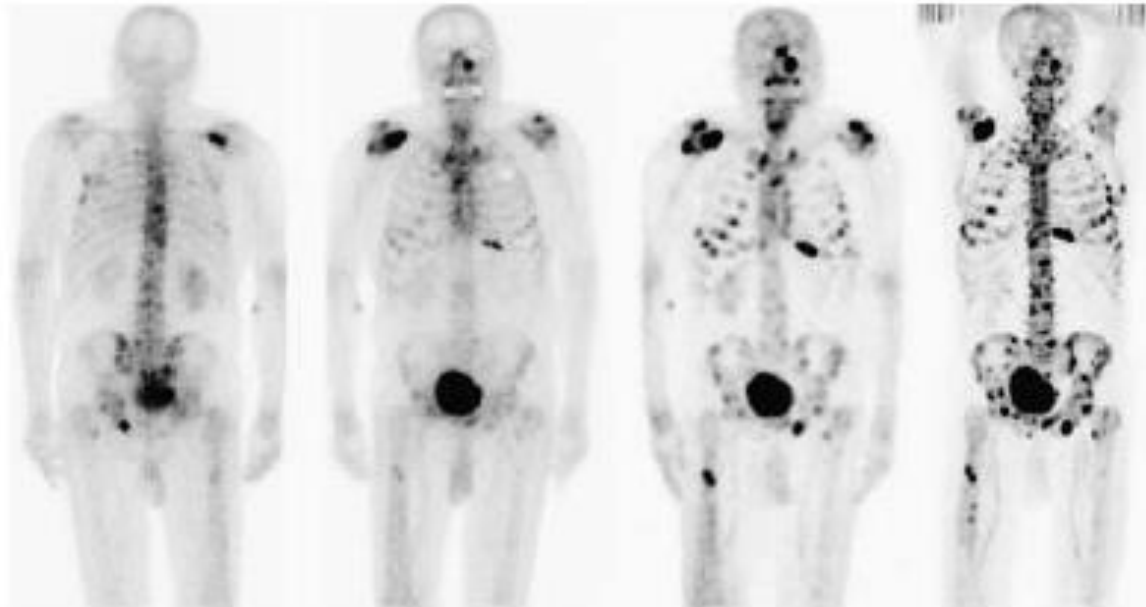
An 82-y-old patient with numerous bone metastases. From left to right: posterior and anterior planar BS, multi-FOV SPECT, and ^{18}F -Fluoride PET images. More lesions are detected on SPECT compared with planar images and on ^{18}F -Fluoride PET compared with SPECT images.
